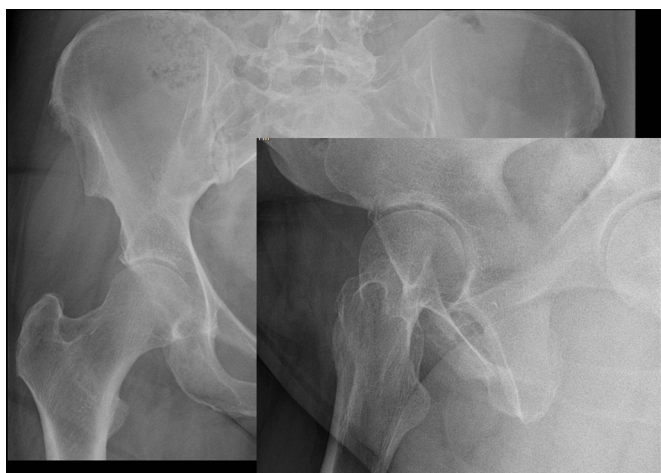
X-ray of the right hip.
